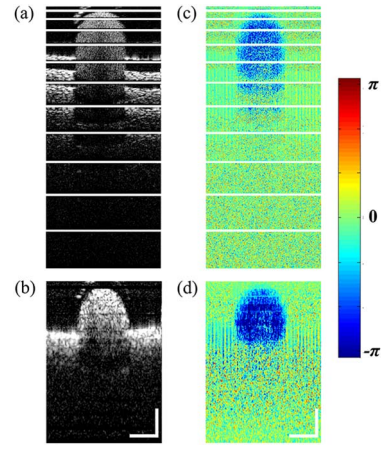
Structural and phase difference images of a $300 \mu\text{m}$ capillary tube filled with 5% intralipid solution with a Doppler angle of 50° . (a) The successive structural images corresponding to twelve orders of reflection. The scan range for the first order was $\sim 60 \mu\text{m}$ and the twelfth order was $\sim 720 \mu\text{m}$. (b) Stitched image of all twelve orders shown in (a). (c) The corresponding phase difference images of all orders shown in (a) and (d) the stitched phase difference image. Scale bar: $250 \mu\text{m}$.
